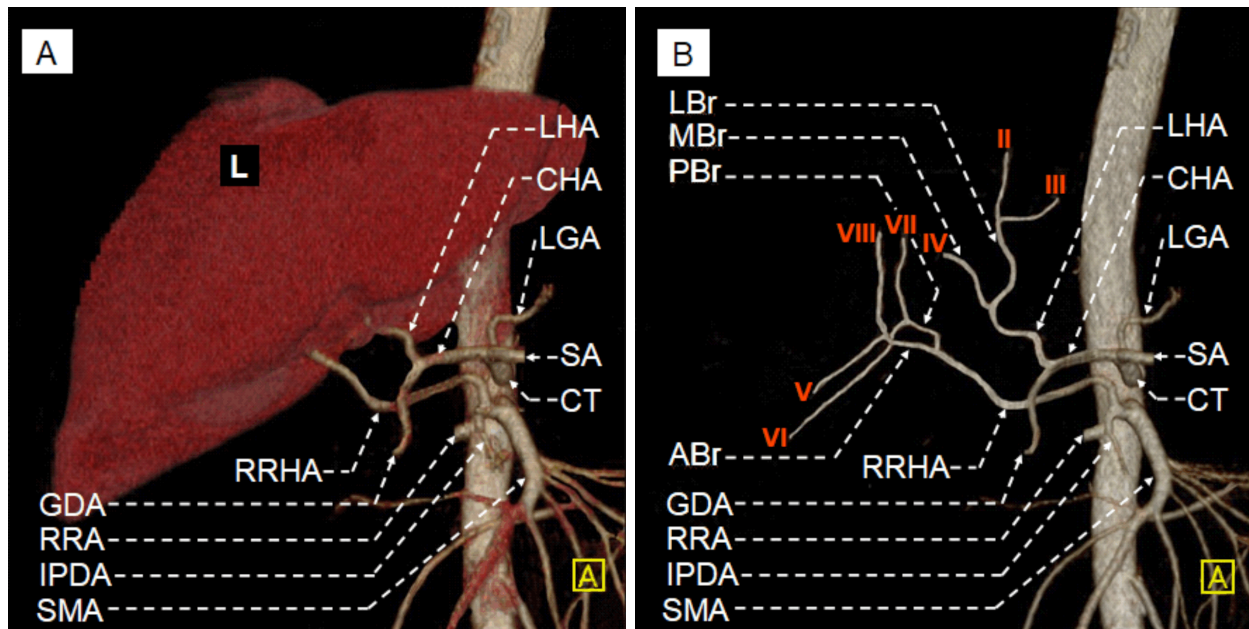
MDCT angiographies with 3D reconstruction of the liver with the abdominal part of aorta, celiac trunk, superior mesenteric artery and replaced right hepatic artery arising from inferior pancreaticoduodenal artery – coronal aspect: (A) VRT image with the liver in situ; (B) VRT image after subtraction of the liver parenchyma. MDCT: Multidetector computed tomography; 3D: Three-dimensional; VRT: Volume rendering technique; L: Liver; CT: Celiac trunk; CHA: Common hepatic artery; LGA: Left gastric artery; SA: Splenic artery; GDA: Gastroduodenal artery; LHA: Left hepatic artery; LBr: Lateral branch; MBr: Medial branch; RRA: Right renal artery; SMA: Superior mesenteric artery; IPDA: Inferior pancreaticoduodenal artery; RRHA: Replaced right hepatic artery; ABr: Anterior branch; PBr: Posterior branch; II–VIII: Hepatic segments from II to VIII.
